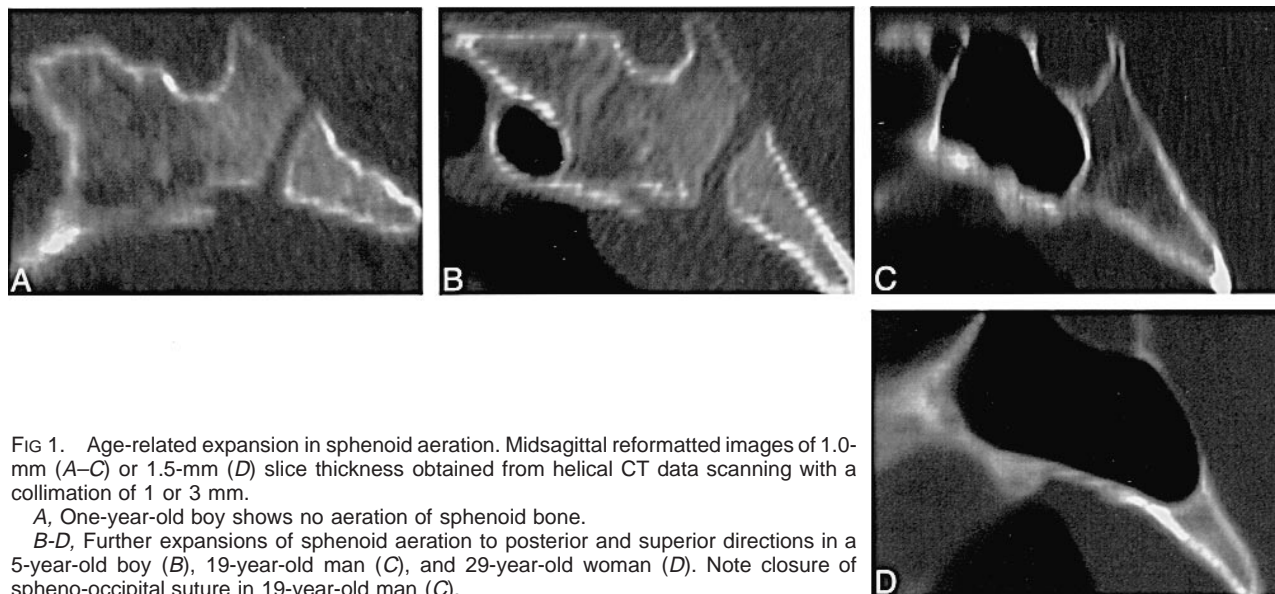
Age-related expansion in sphenoid aeration. Midsagittal reformatted images of 1.0-mm (A-C) or 1.5-mm (D) slice thickness obtained from helical CT data scanning with a collimation of 1 or 3 mm.
